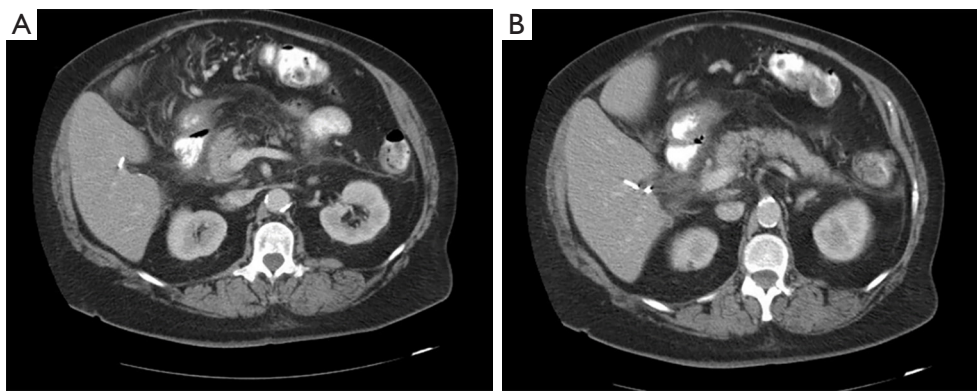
Cross sectional images of contrast enhanced computerized tomography (CT) scan of the abdomen demonstrating peri pancreatic fat stranding (A) and pancreatitis of head and body (B).
